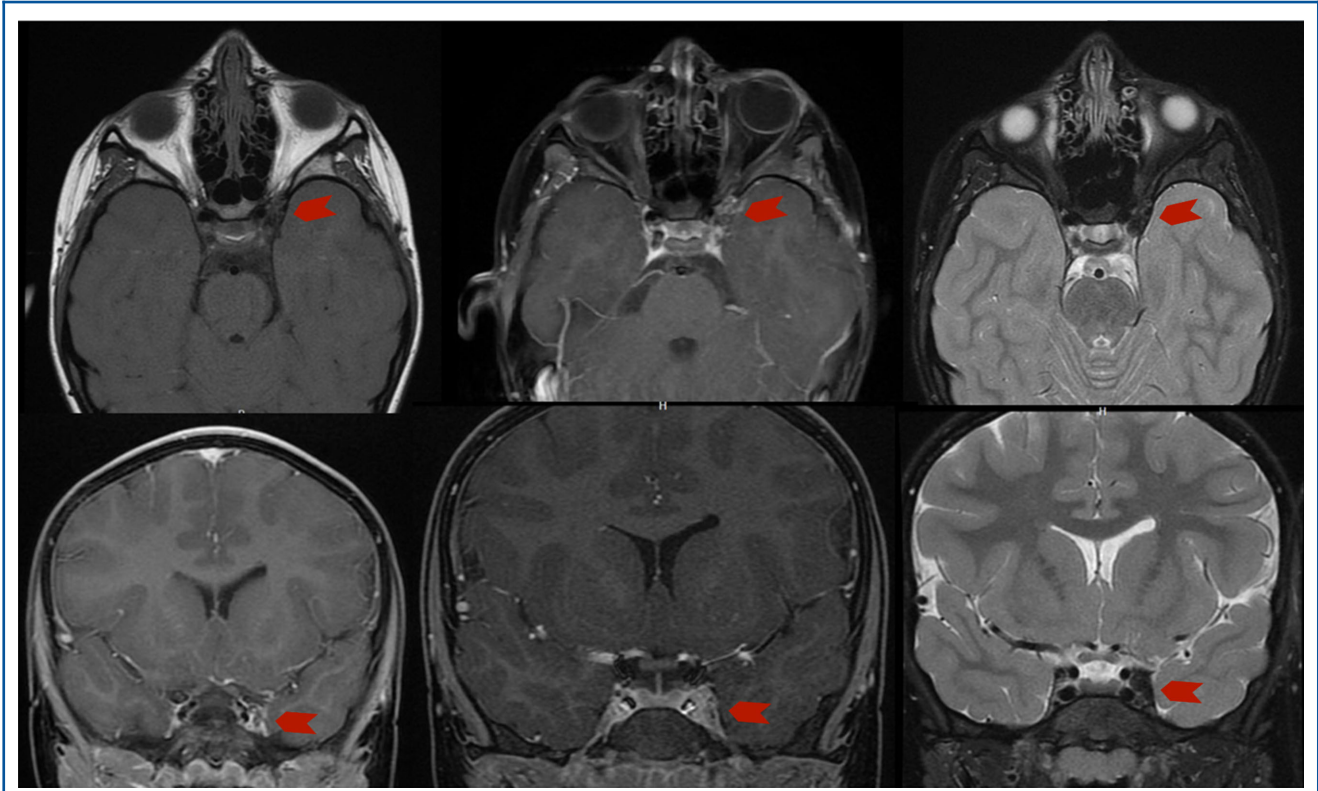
Preoperative MRI showing a left, T1 and T2 hypodense, intracavernous lesion without contrast enhancement, suggestive of a cavernous malformation.
